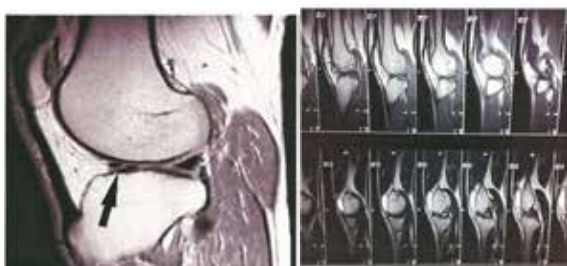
26 &27: MRI Left knee
